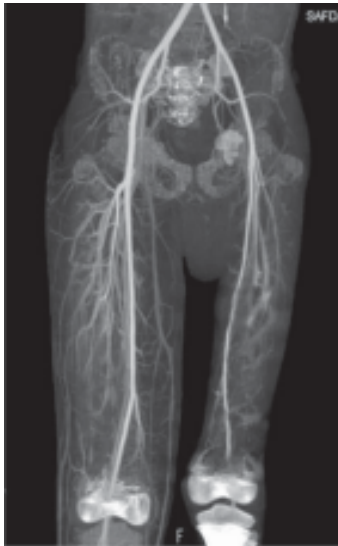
Volume Rendered(MIP) coronal CT angiography(venous phase)image of bilateral thighs show multiple prominent venous channels on the right side.
